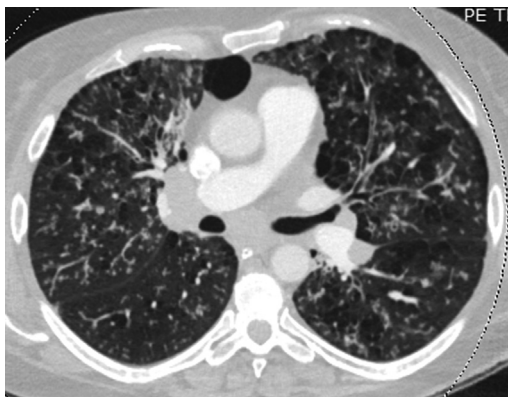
Haemophilus influenzae* pneumonia in a 50-year-old woman with emphysema. Axial chest CT demonstrates numerous centrilobular nodules throughout both lungs, some of which have tree-in-bud morphology, consistent with infectious bronchiolitis imaging appearance is very similar to the previous cases of parainfluenza pneumonia.
